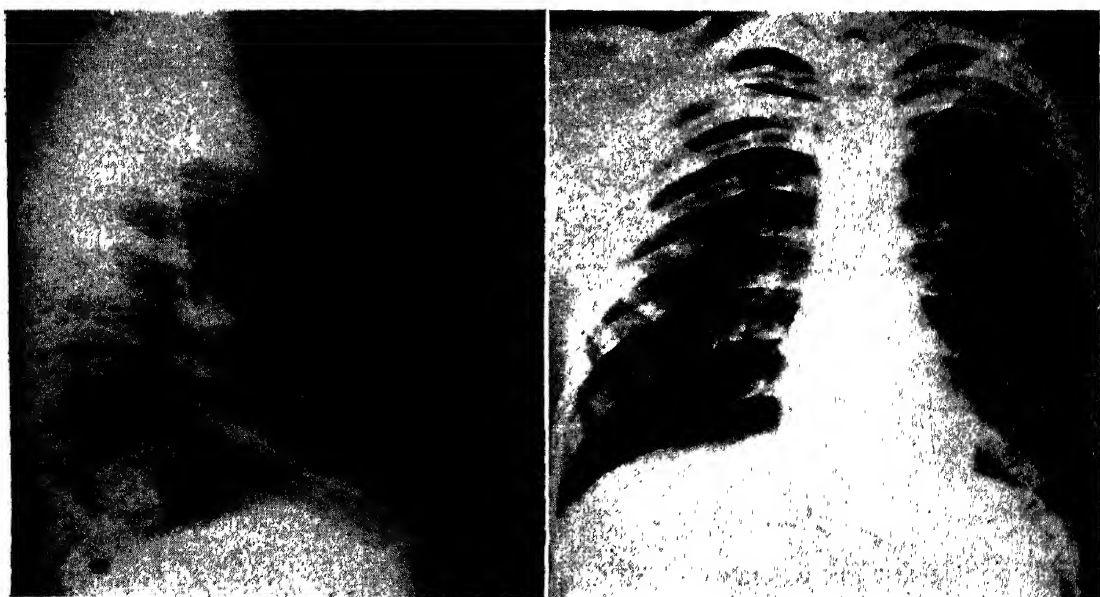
Characteristic localized segmental or lobular pneumococcus pneumonia of location and size similar to Fig. 11. (A. E. Seeds and M. L. Mazer: *Am. J. Roentgenol.*)
